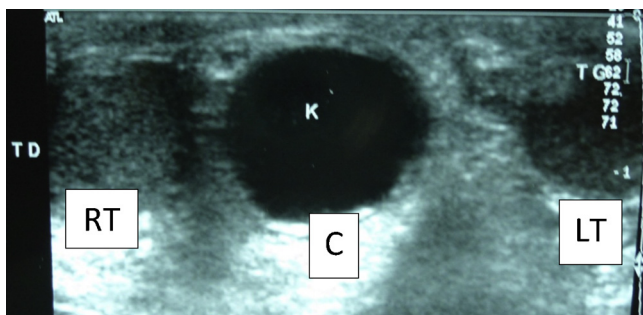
Ultrasonographic appearance of the two. The cysts are independent of the right testicle. RT: right testicle; LT: left testicle, C: cyst.
